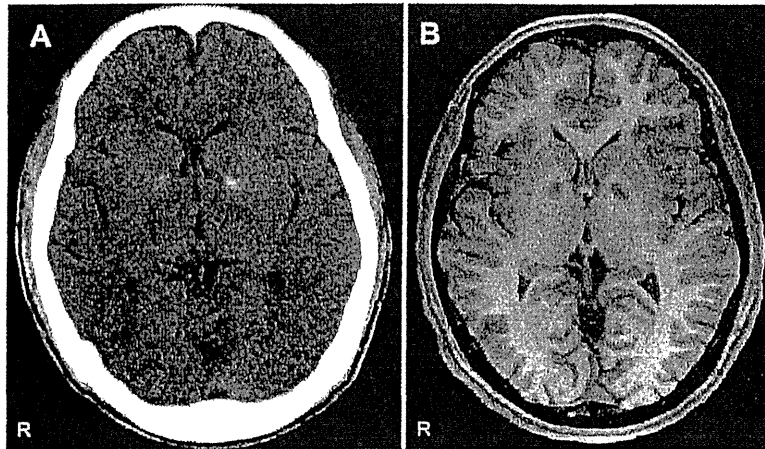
(A) Cerebral CT scan showing intense bilateral symmetrical calcification in the basal ganglia. (B) Cerebral MRI showing hypointensity in the bilateral basal ganglia on T1-weighted image.
